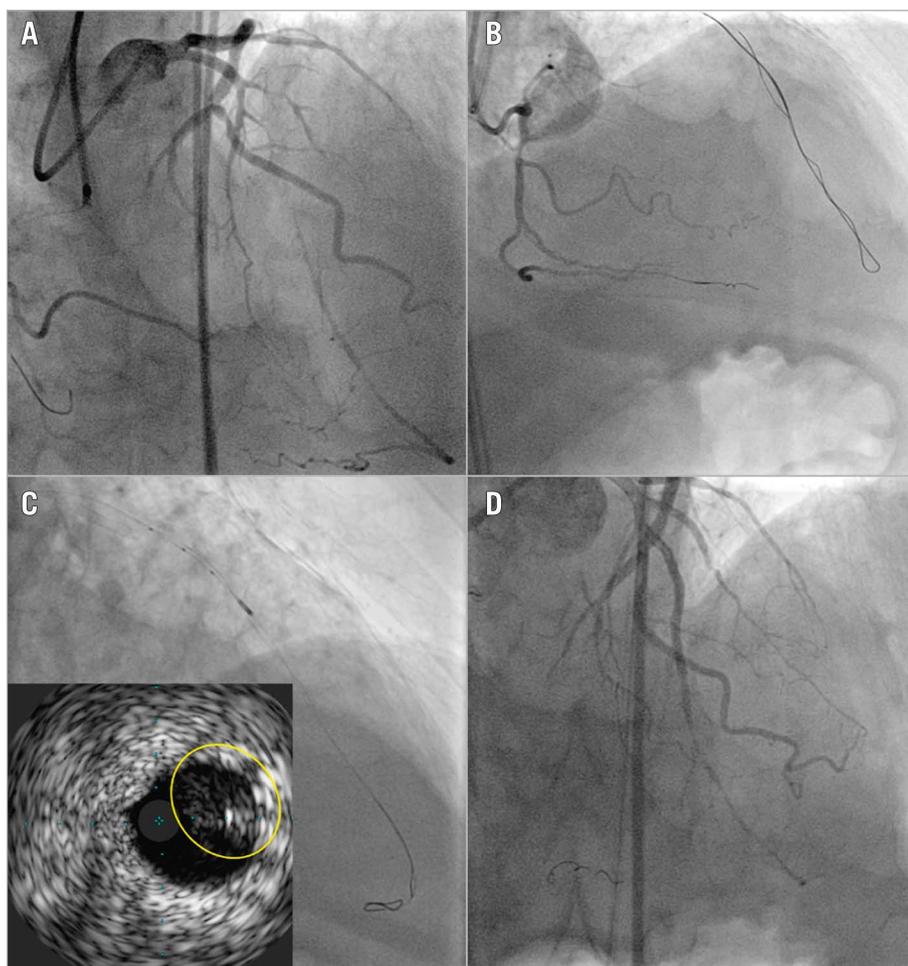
IVUS-guided antegrade re-entry. A) Angiography of a CTO of the proximal LAD. B) A knuckled Fielder XT-wire advanced distal to the CTO. C) IVUS confirms the subintimal distal position of the knuckled wire and facilitates re-entry into the true distal lumen using a Confianza 12g guidewire (yellow circle). D) Final angiographic result. CTO: chronic total occlusion; IVUS: intravascular ultrasound; LAD: left anterior descending artery
